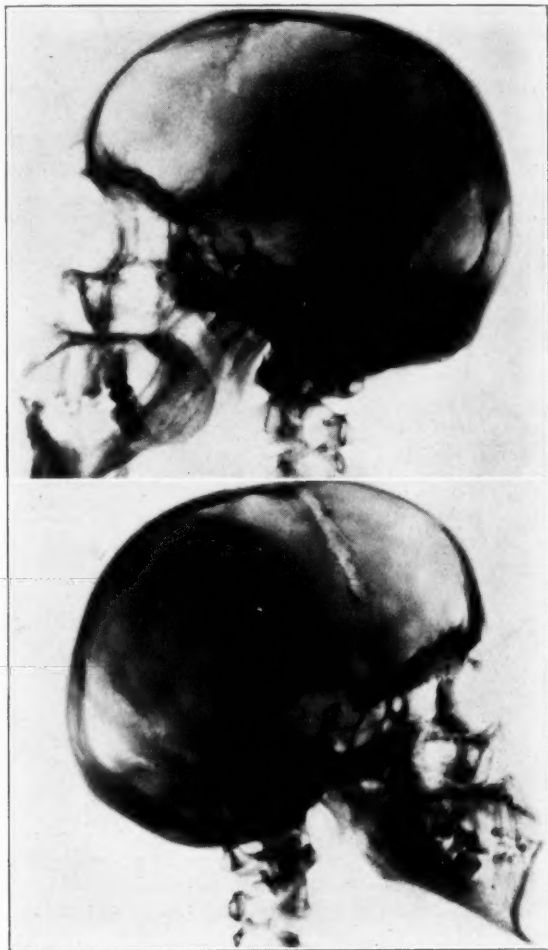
The upper roentgenogram shows the brother's skull with a large sella and widening of the occipitoparietal suture, and the lower, the sister's skull, with separation of both frontoparietal and occipitoparietal sutures and increased convolutional markings.
